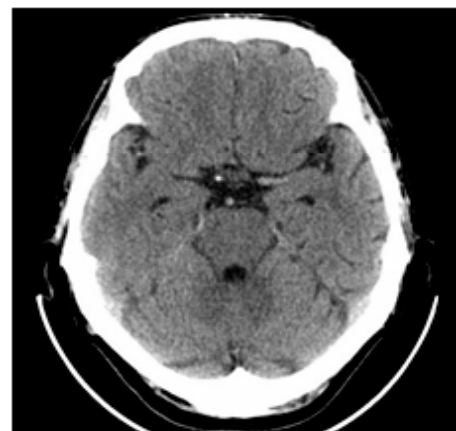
Same patient T., 62 years old, a year after transcatheter intracerebral laser exposure. Brain CT.
